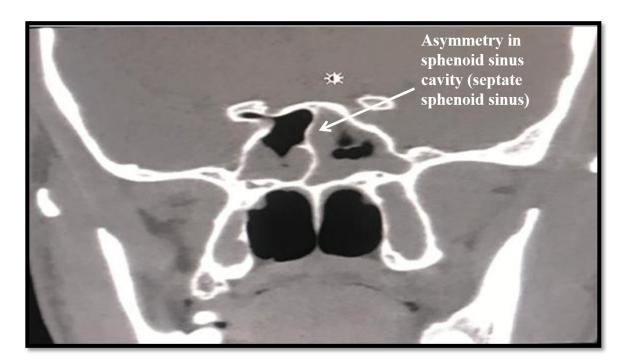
Coronal view of CT-PNS showing asymmetry in sphenoid sinus cavity (septate sphenoid sinus) in symptomatic patient of sinusitis
